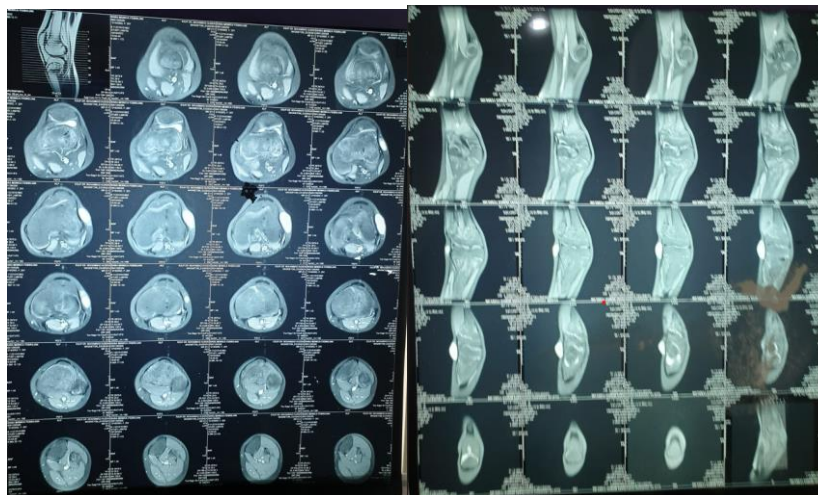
Genu MRI examination.
